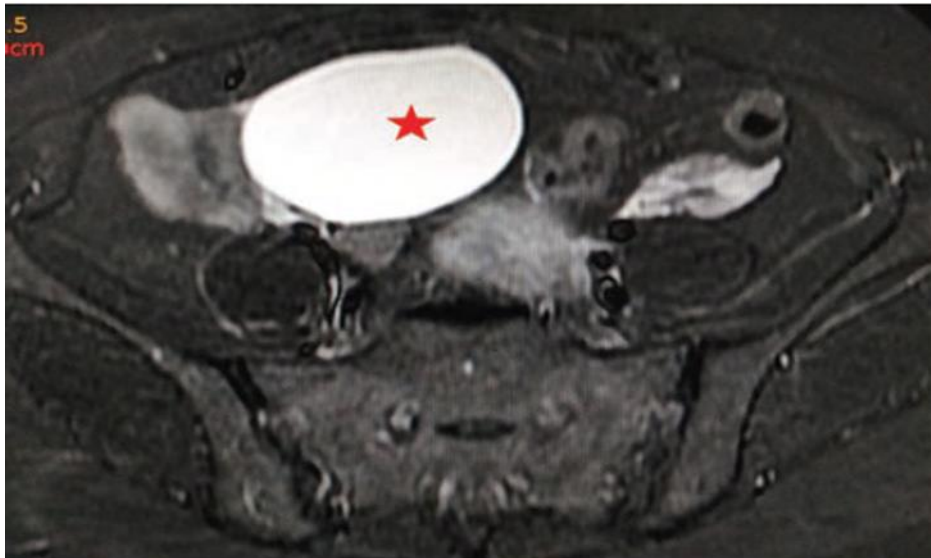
Axial STIR MRI demonstrating a well-defined nonenhancing thin-walled cystic lesion (star) arising from the right adnexa, features are of concern for ovarian etiology, likely serous cystadenoma. MRI, magnetic resonance imaging.
